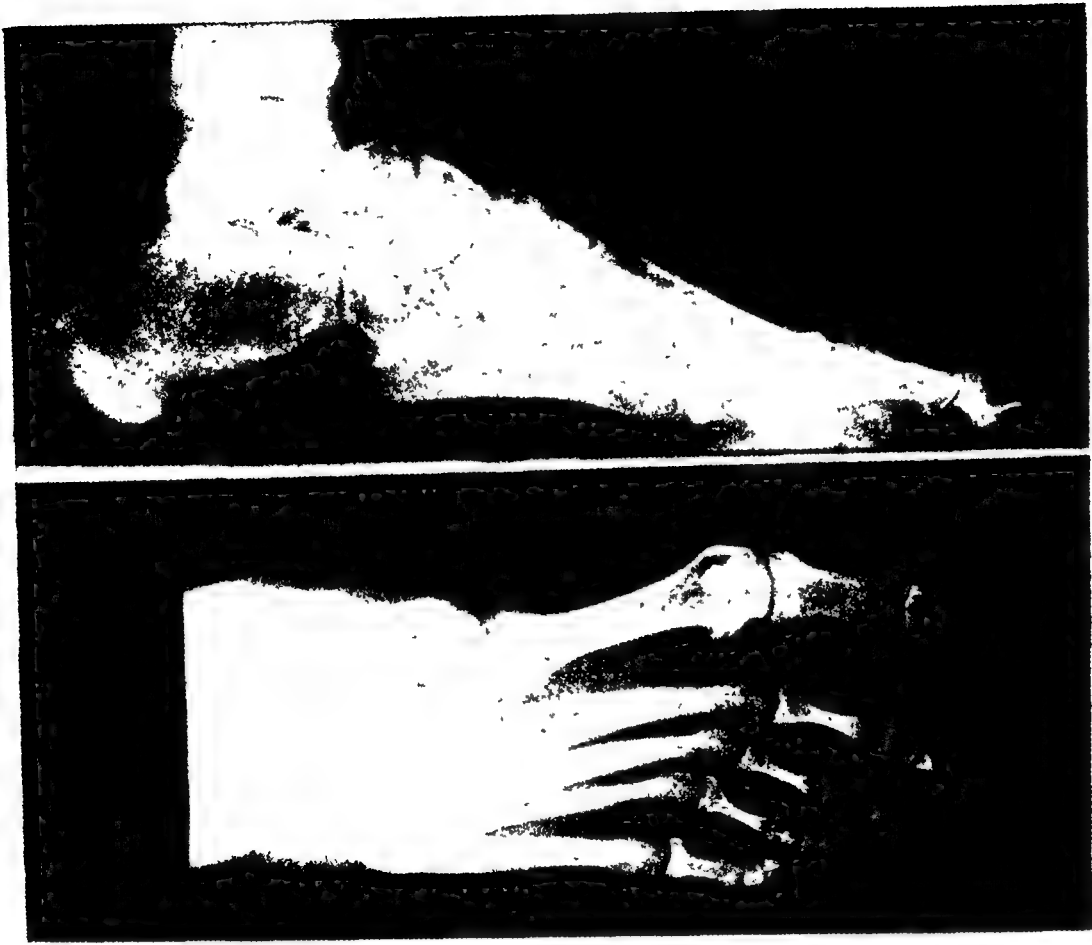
RADIOGRAPHIC FEATURES OF PES ADDUCTUS. *Dorso-plantar view.* (1) Inversion superimposes bases of metatarsal shafts in lateral shift (2) Note varus position of metatarsal shafts as metatarsal heads shift medially. (3) Atavistic cuneiform directs first metatarsal into varus (4) Adduction increases length ratio of first metatarsal. *Lateral view* (5) The talus is seated high on the subtalar joint. (6) Sinus tarsi is exaggerated. *Other features.* Inversion appraised by lateral overlap of calcaneus. The medial arch segment rises above the cuboid level.
